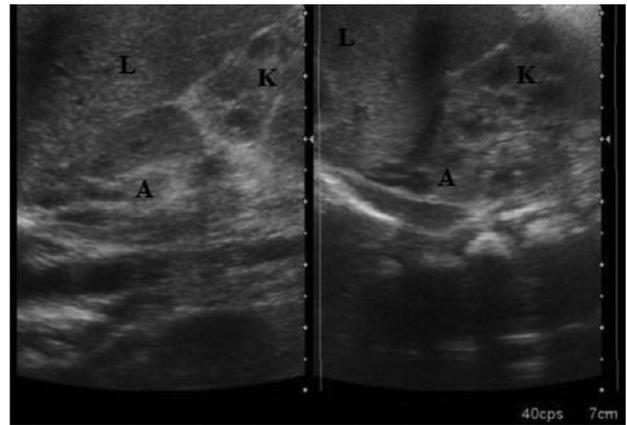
Abdominal ultrasound showing signs of an evolving right adrenal hemorrhage (L: liver, K: kidney, A: adrenal gland).
